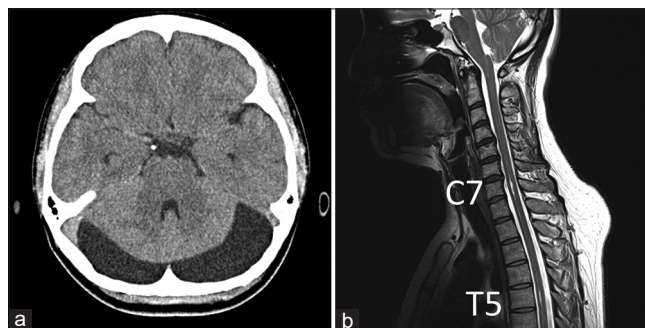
The brain CT and brain/cervical MR studies demonstrated a posterior fossa arachnoid cyst (a), with an acquired Chiari I malformation with C7-T5 syrinx (b).
